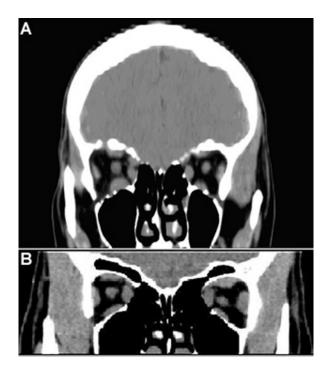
Coronal CT images from case 1 showing (A) enlargement of the belly of both medial and inferior recta, of right superior rectus and superior oblique.
